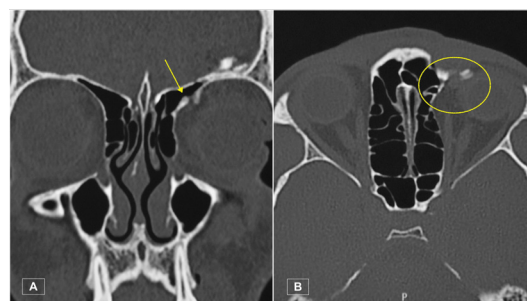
CT scan of the orbit on the coronal view shows the orbital roof fracture at the site of trochlea (A). On the axial view, CT scan shows entrapment of superior oblique muscle at the site of fracture (B).
